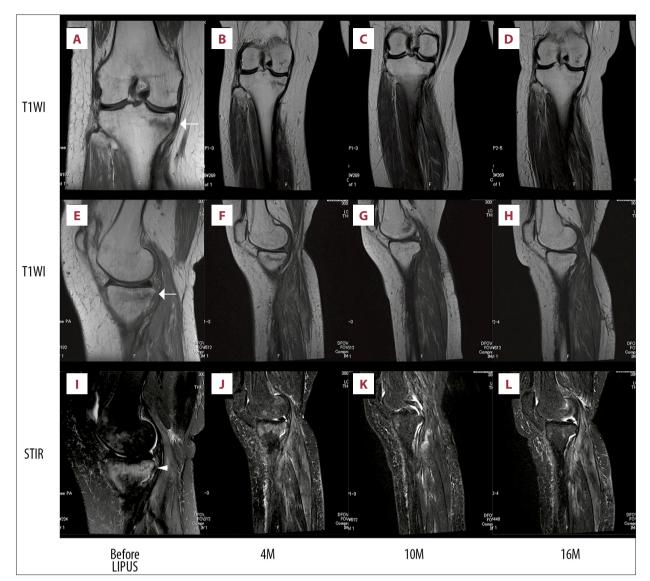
MRI signals and time course of the resolution for the insufficiency fracture in the proximal medial tibia. Coronal T1-weighted images (A-D), sagittal T1-weighted images (E-H), and sagittal T2-weighted images with fat suppression of the right knee taken immediately after the onset of the knee pain, and 4 months, 10 months, and 16 months after initiation of LIPUS therapy. Low signal intensity (A and E, arrows) on T1-weighted images and high signal intensity (I, arrowhead) on short TI inversion recovery (STIR) images in the proximal medial tibia disappeared over time. T1WI, T1-weighted images; STIR, short TI inversion recovery; LIPUS, low-intensity pulsed ultrasound; M, months.
